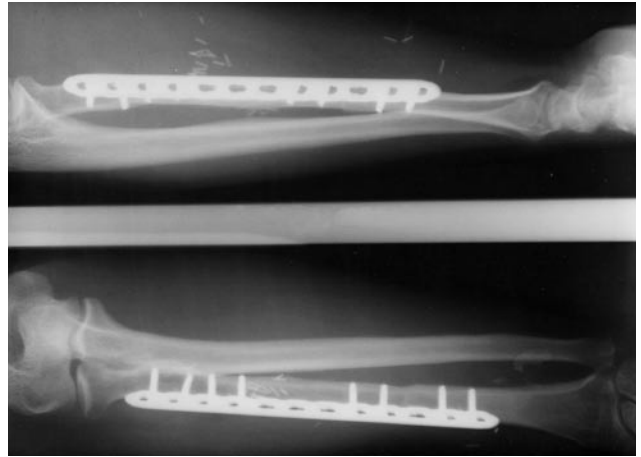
Anteroposterior and lateral radiographs 12 months after fibula autograft reconstruction. Note cortical bridging at both osteotomy sites and maintenance of radial length.
